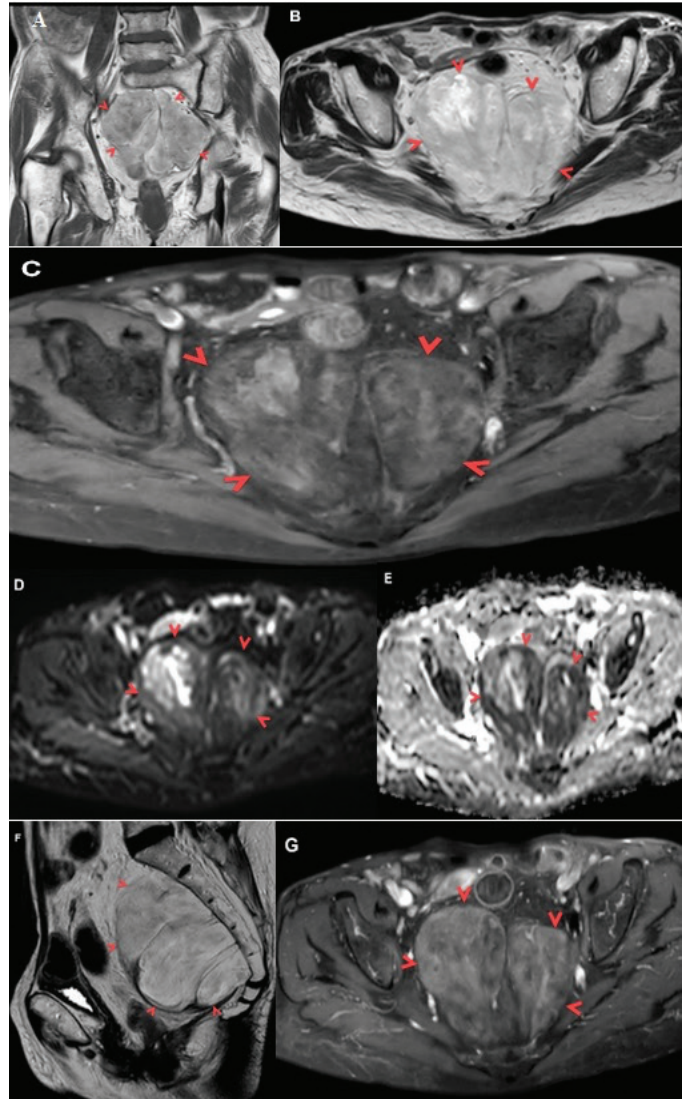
(A) Coronal T1-weighted and (B) Axial T2-weighted magnetic resonance (MR) images show well-defined, encapsulated and mildly hyperintense mass in the presacral space (arrowheads). Note the anteriorly displaced rectum (dashed arrow) and uterus (arrow). (C) Axial T1-weighted fat-suppressed MR image shows signal dropout in the lesion due to the fat component (arrowheads). (D) Axial diffusion-weighted and (E) apparent diffusion coefficient (ADC) map image demonstrates mild diffusion restriction with an ADC value of $0.92 \times 10^{-3} \text{ mm}^2/\text{sec}$ (arrowheads). (F) Sagittal T2-weighted MR image shows a hypointense capsule of the presacral lesion (arrowheads). (G) Axial contrast-enhanced T1-weighted fat-suppressed MR image shows heterogeneous contrast enhancement in the lesion (arrowheads)
